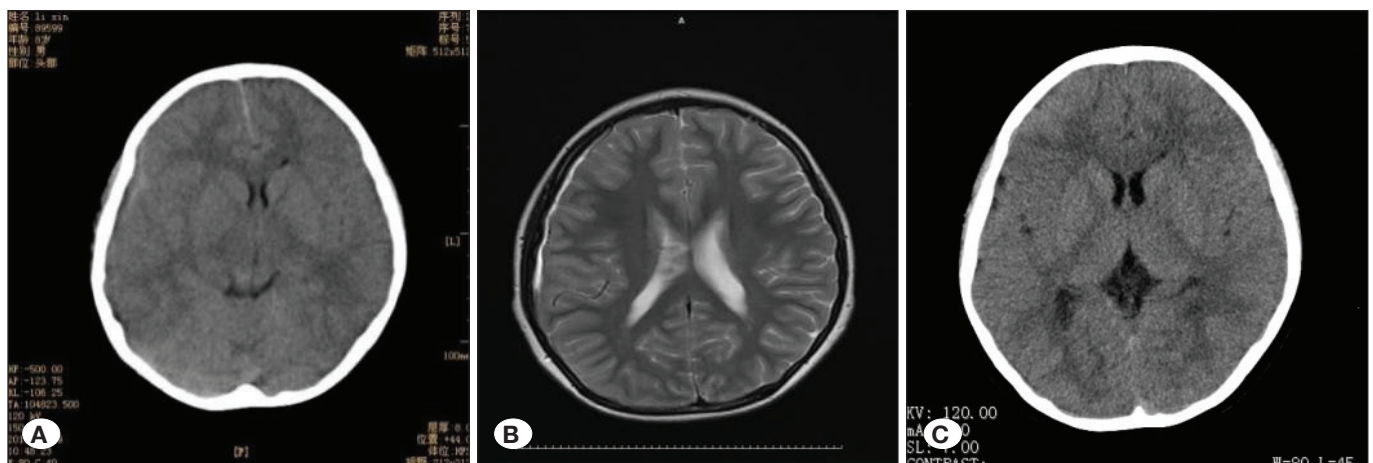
Imaging data of case 2. A) Cerebral CT scanning upon hospitalization showed a right temporal subdural hematoma and subarachnoid hemorrhage. B) Cranial MRI upon hospitalization suggested a subacute subdural hematoma in the right temporal lobe. C) Cerebral CT review after 6 months showed that the hematoma was absorbed.
